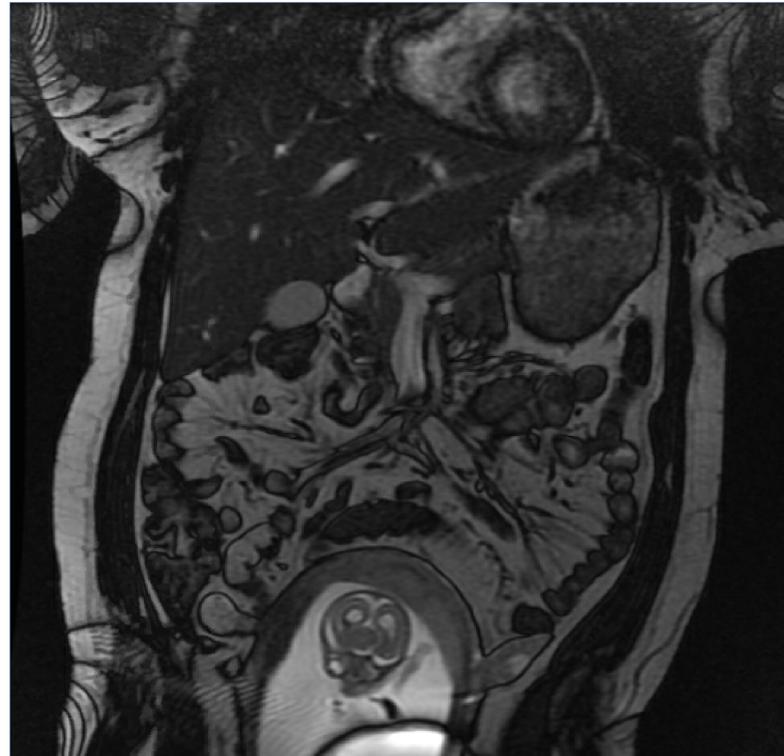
MRI of the abdomen
